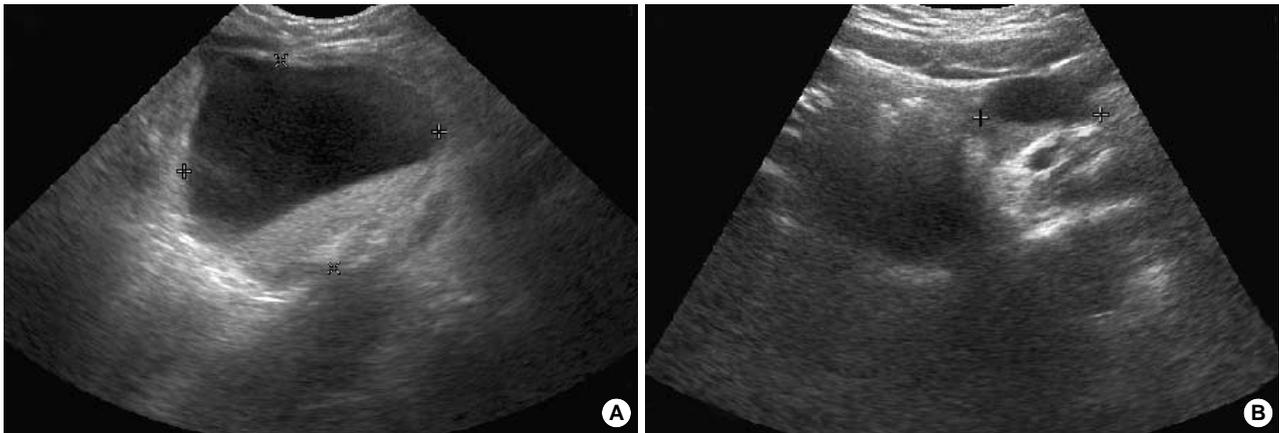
(A) Complex ovarian cyst: postnatal sonography of case 16 at 1 month, (B) Complex ovarian cyst: postnatal sonography of case 16 at 10 month.
